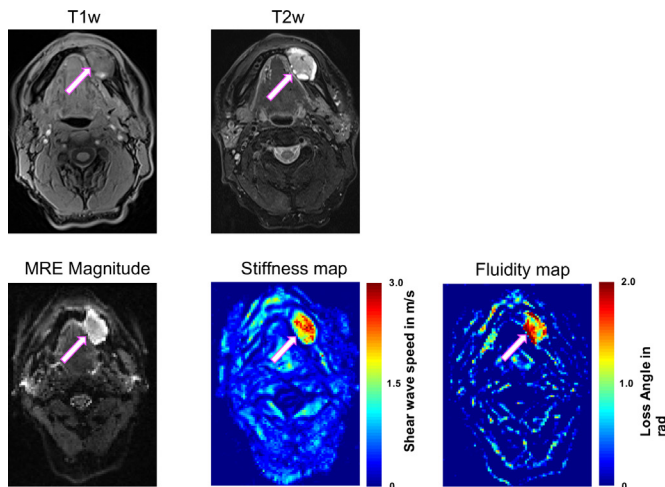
Axial T1-weighted (T1w; VIBE DIXON) and T2-weighted (T2w; TSE DIXON, fat saturated) MR images and magnetic resonance elastography (MRE) magnitude, stiffness and fluidity maps of the ameloblastoma (arrow) in the left mandible. High stiffness and fluidity allow clear identification of the tumour extent. Scale; stiffness, red=stiff, blue=soft; fluidity, red=fluid, blue=solid. Volumetric interpolated breath-hold examination (VIBE)-Dixon, fat saturated; Turbo-Spin-Echo (TSE)-Dixon, fat saturated.
